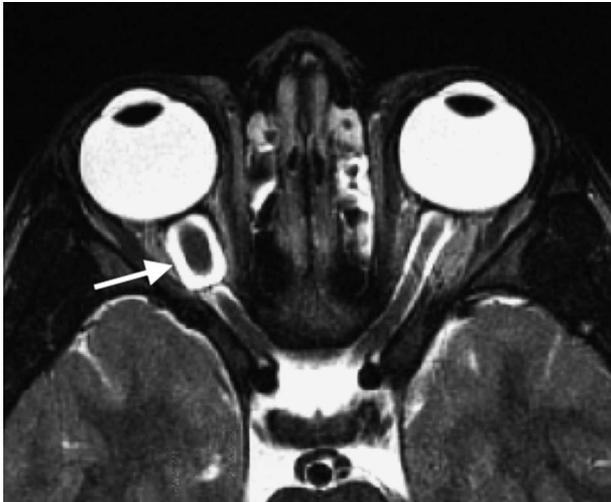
T2 axial MRI demonstrating enlargement and kinking of the intraorbital portion of the right optic nerve (*arrow*), consistent with an optic nerve glioma. There was no extension beyond the optic canal, and the optic nerve did not enhance.
